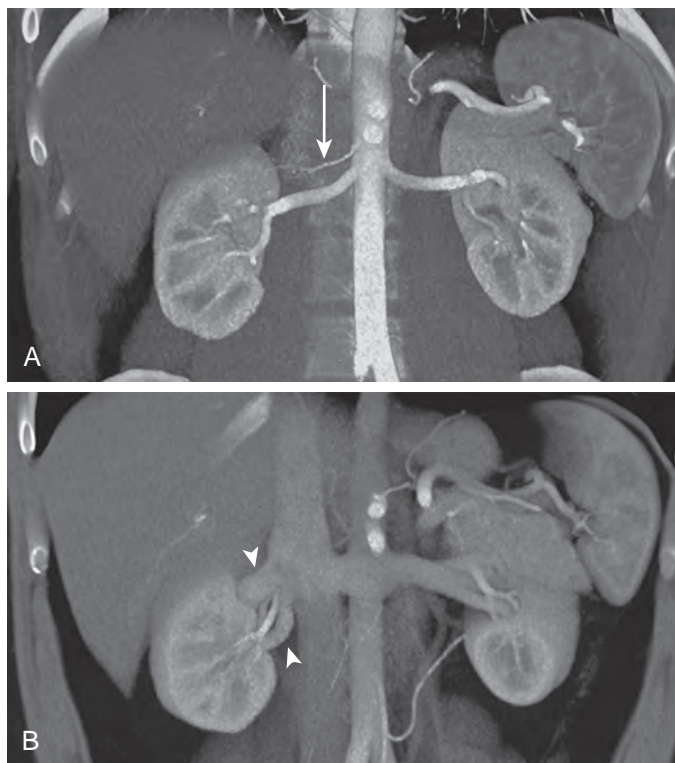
CT angiogram for evaluation of potential renal donor. A. Small accessory right renal artery (arrow). B. There are also two right renal veins (arrowheads).
